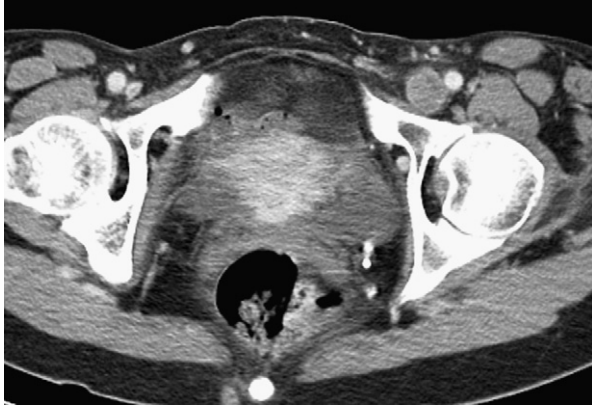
Axial contrast-enhanced CT image. The left common femoral vein is expanded by intra-luminal low attenuation material, thought at the time to be consistent with deep vein thrombosis.
